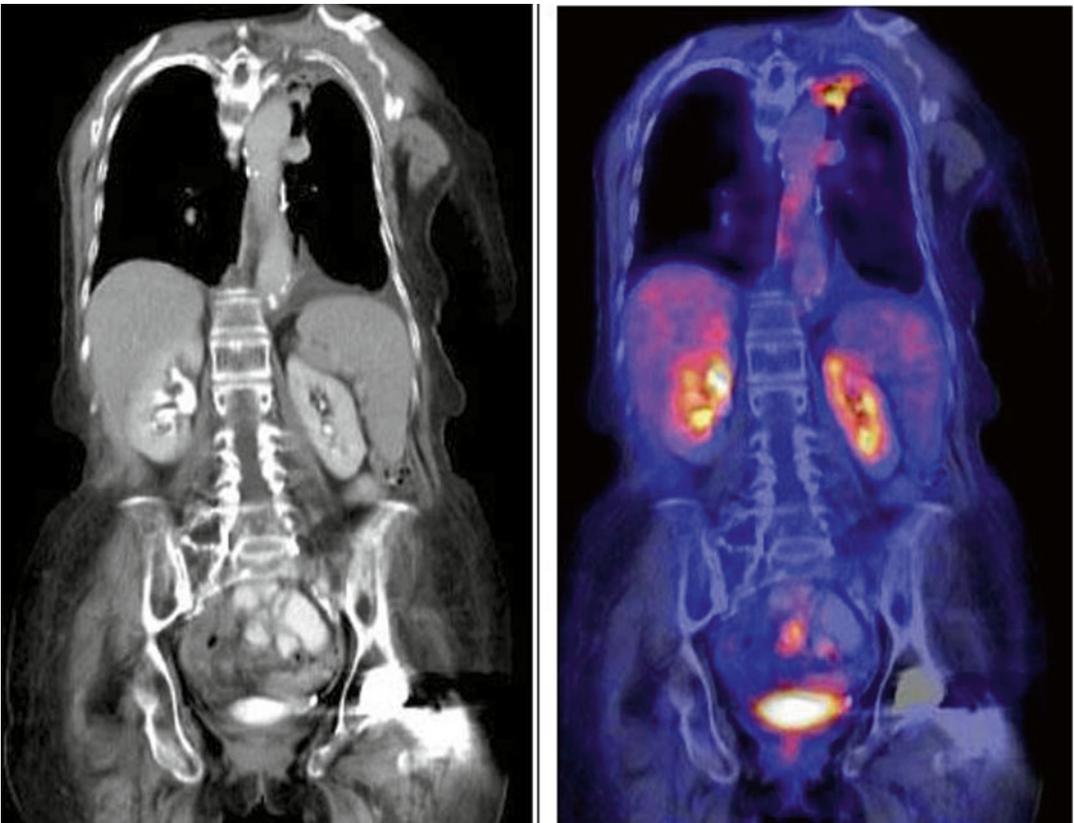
Surveillance PET/CT (2 yrs. following radiation therapy), coronal view
